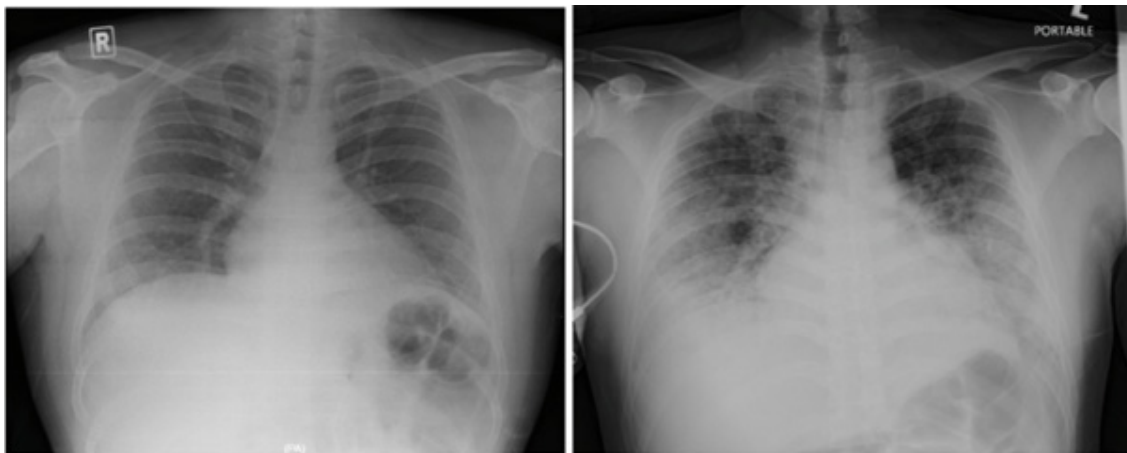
Chest X-ray (Left: Upon presentation, clear; Right: 12 hours post admission, bilateral diffuse alveolar shadowing).
